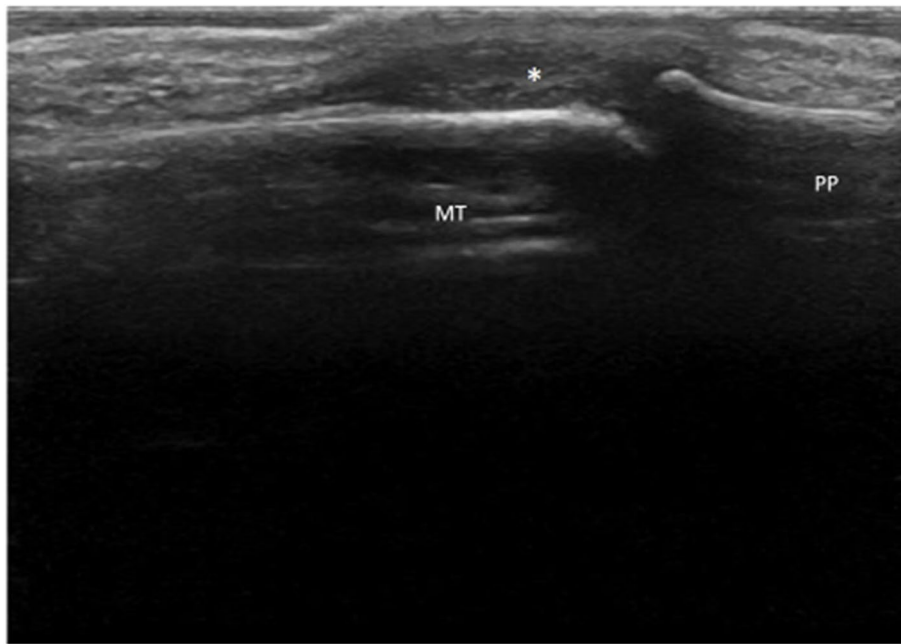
Dorsal longitudinal gray scale ultrasound scan of the 2nd MTP joint showing synovitis (asterisk)
